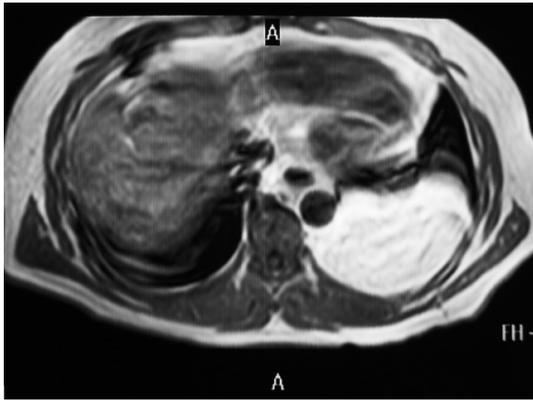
MRI of thorax; the lesion is hyperintense in T2 weighted images
